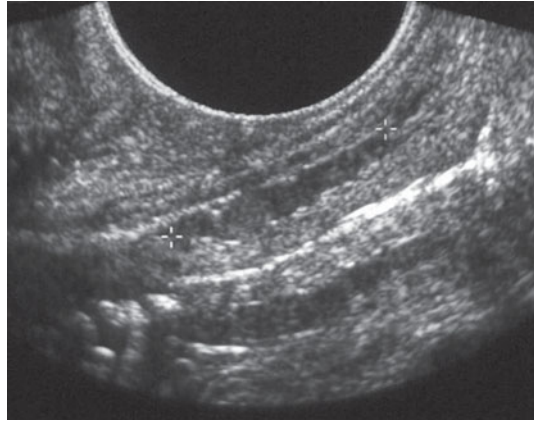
Transrectal ultrasonography. Endometriosis of the rectovaginal septum. A solid hypoechoic plaque is visible in the rectovaginal septum (crosses)
